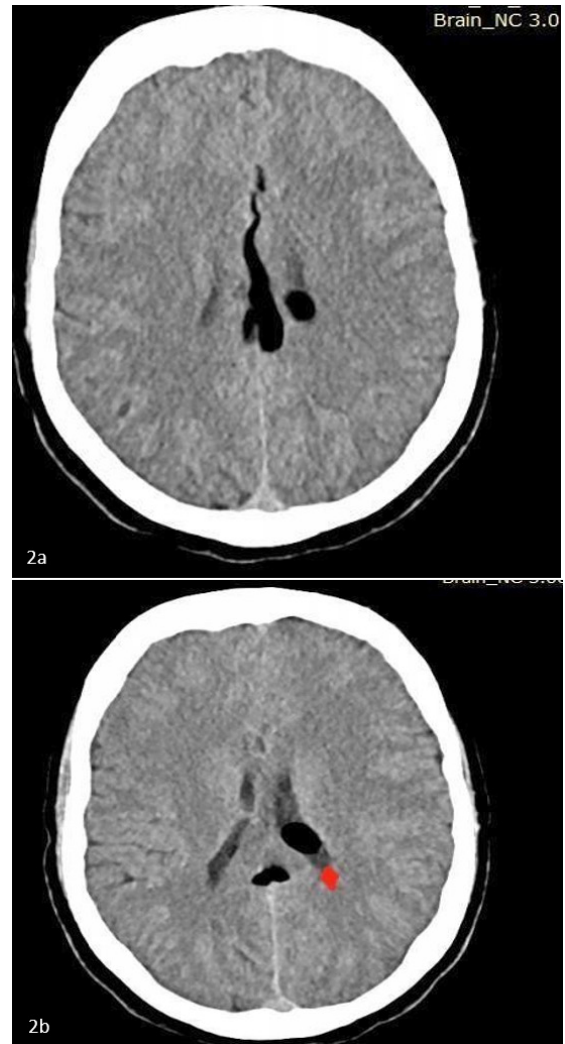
Axial non-contrast CT scan of the brain showing well defined elongated fat density lesion in the interhemispheric region (figure 2a), which has extension to the into the posterior portion of body of the left lateral ventricle (represented by red arrow in figure 2b)
